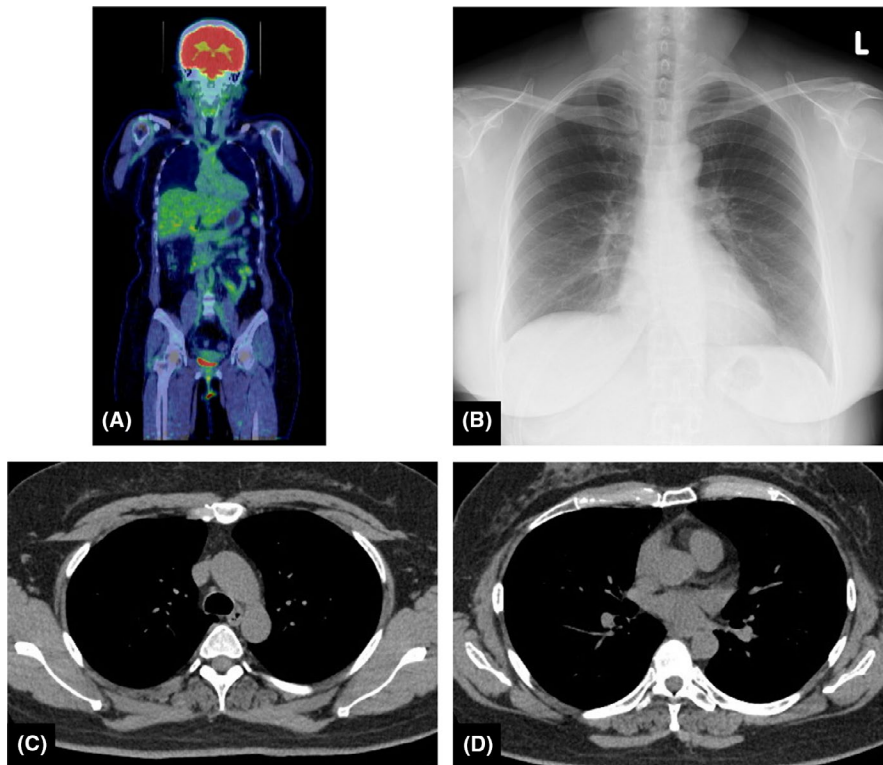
Proton emission tomography, two months after discontinuing maintenance pemetrexed, shows no enhanced signal throughout the body (A). Chest X-ray after 51 mo (B) and chest computed tomography at 54 mo after discontinuing PMT show no recurrence (C, D)
